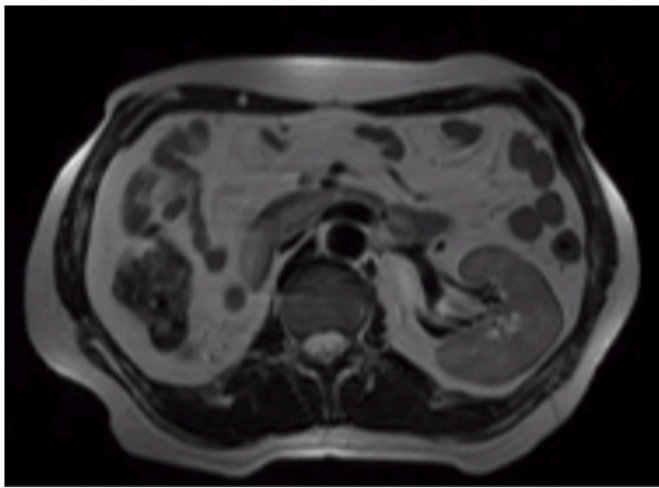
MRI scan of a right renal agenesis (Axial T2-weighted image).
